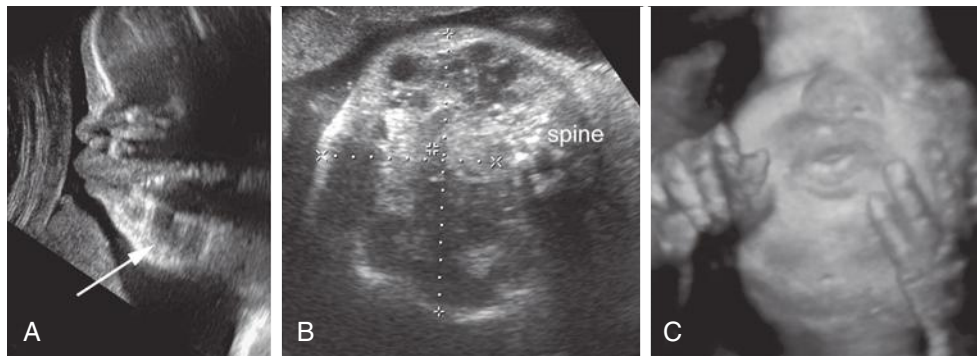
Although the antenatal diagnosis was cervical teratoma, this fetus was found at birth to have a cavernous lymphangioma infiltrating the neck tissues. A and B, Two-dimensional sonograms demonstrating the large neck mass. C, Surface rendered 3D sonogram demonstrating the mass.
